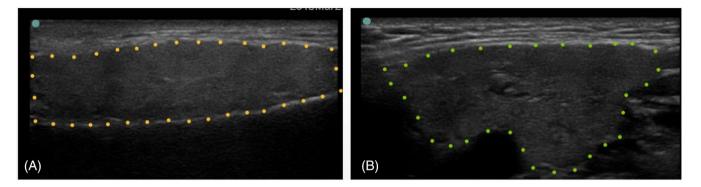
Ultrasound images of the parotid and submandibular glands. (A) The parotid gland is inside the yellow dotted line; (B) the submandibular gland is inside the green dotted line.
